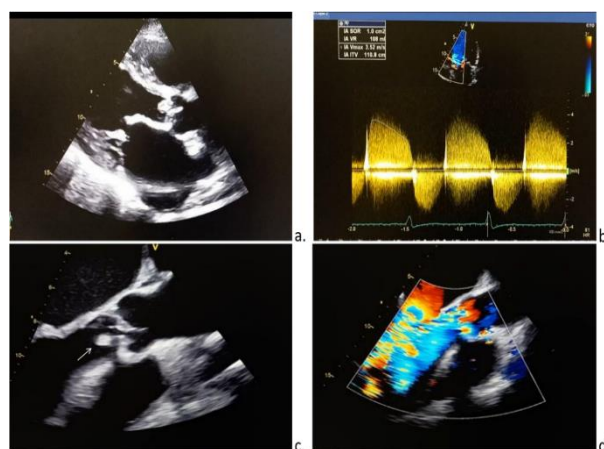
A, Transthoracic echocardiographic (TTE) image showing vegetation on the aortic valve. B, TTE image showing quantification of severe aortic regurgitation. C, TEE image showing an 11-mm vegetation on the aortic valve (white arrow). D, TEE image showing aortic regurgitation extension and accelerated left ventricle filling through the mitral stenosis.
